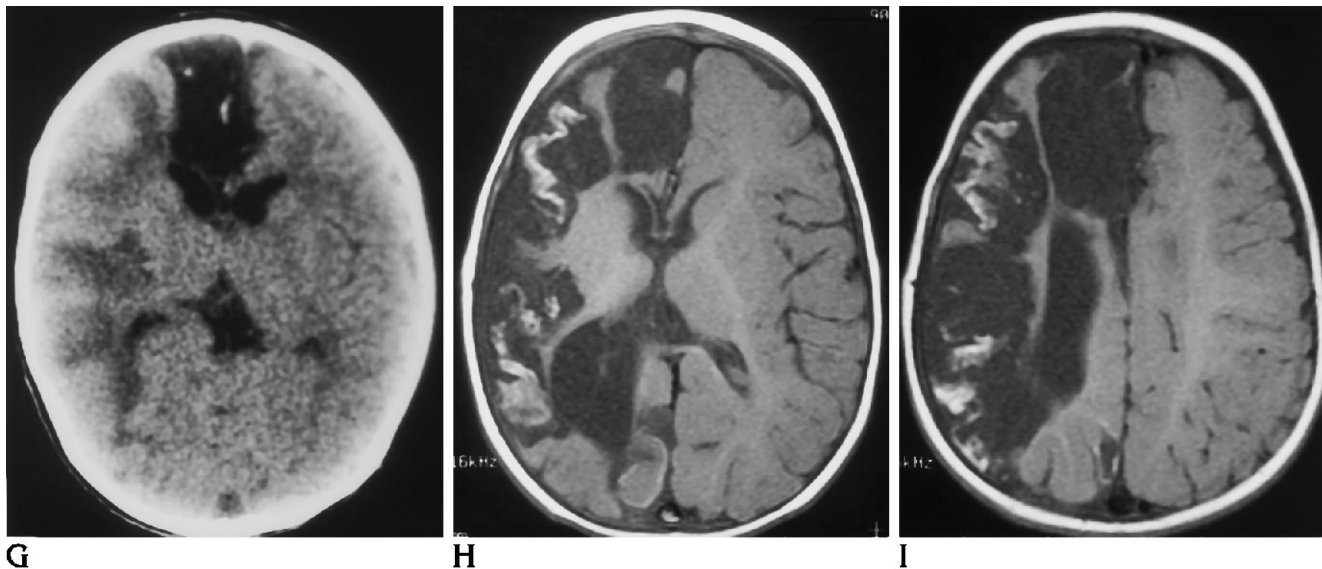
cont'd.* G, CT scan 24 hours after embolization of the territory of the right middle cerebral artery shows local edema and high attenuation secondary to embolic material. Encephalomalacia is present in the anterior cerebral artery territory embolized 10 weeks earlier.
